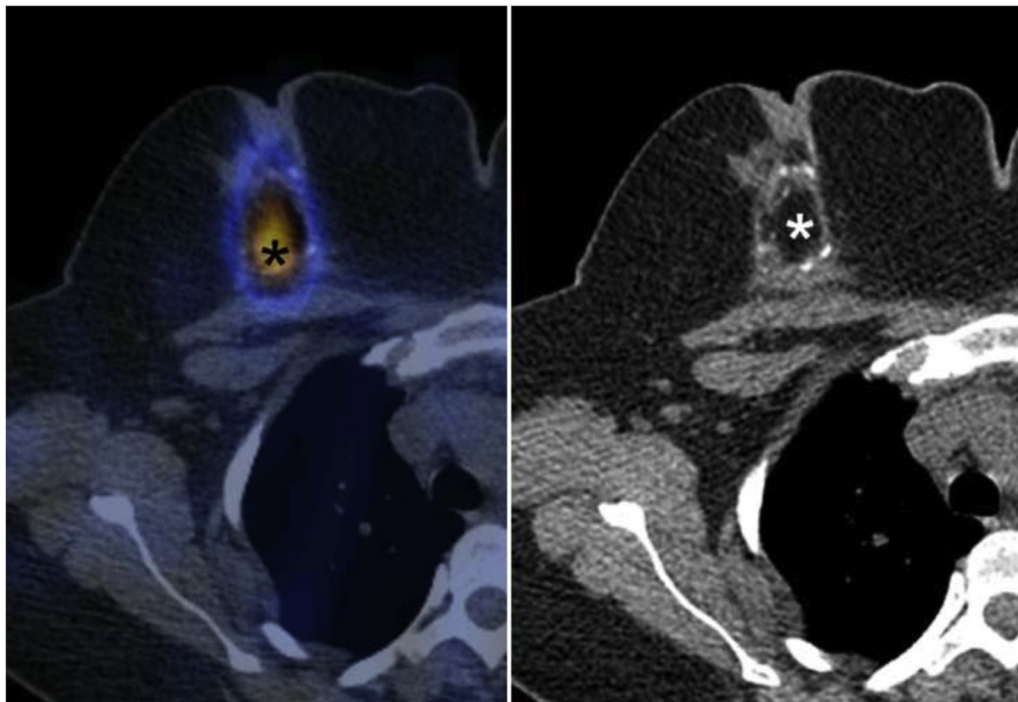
Single-photon emission computed tomography/CT demonstrating focal I-131 uptake in the right breast. The radiotracer uptake is localized to a fat containing well-defined lesion in the right breast, with surrounding rim of linear soft tissue and discontinuous linear calcifications, consistent with fat necrosis (asterisks).
